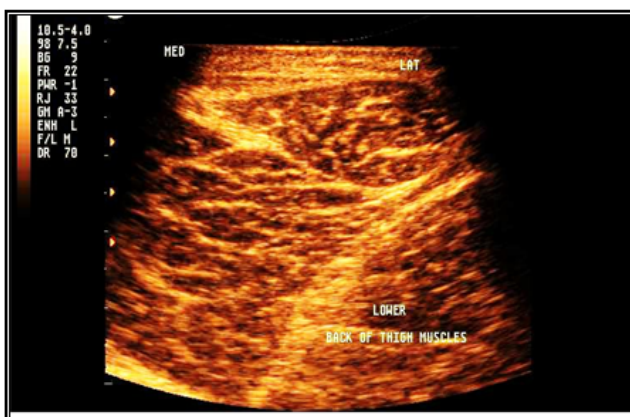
a. Normal 2D sonography of Hamstring muscle complex, b. Multiplanar image analysis with 3D reconstruction of normal muscle
